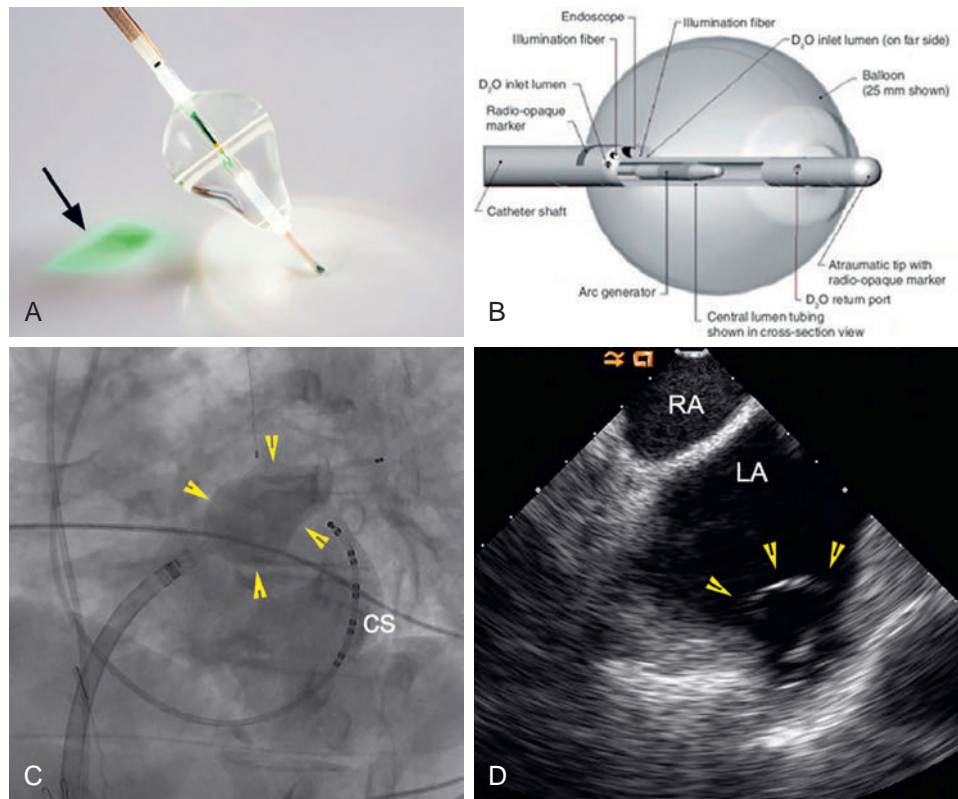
The Laser Ablation Balloon Catheter Technology. (A) The visually guided laser balloon is shown with the aiming and ablation spot of light (arrow). (B) The catheter structure and the inflated balloon. (C) Fluoroscopic image (left anterior oblique projection) of the laser balloon (arrowheads) deployed at the antrum of the left superior pulmonary vein (LSPV). (D) Intracardiac echocardiographic image of the inflated balloon (arrowheads) at the antrum of the LSPV. CS, Coronary sinus; LA, left atrium; RA, right atrium. (A, Modified from CardioFocus, Inc., Marlborough, MA; B, modified from Bordonjon S, Chun KR, Gunawardene M, et al. Endoscopic ablation systems. *Expert Rev Med Devices*. 2013;10:177–183.)
